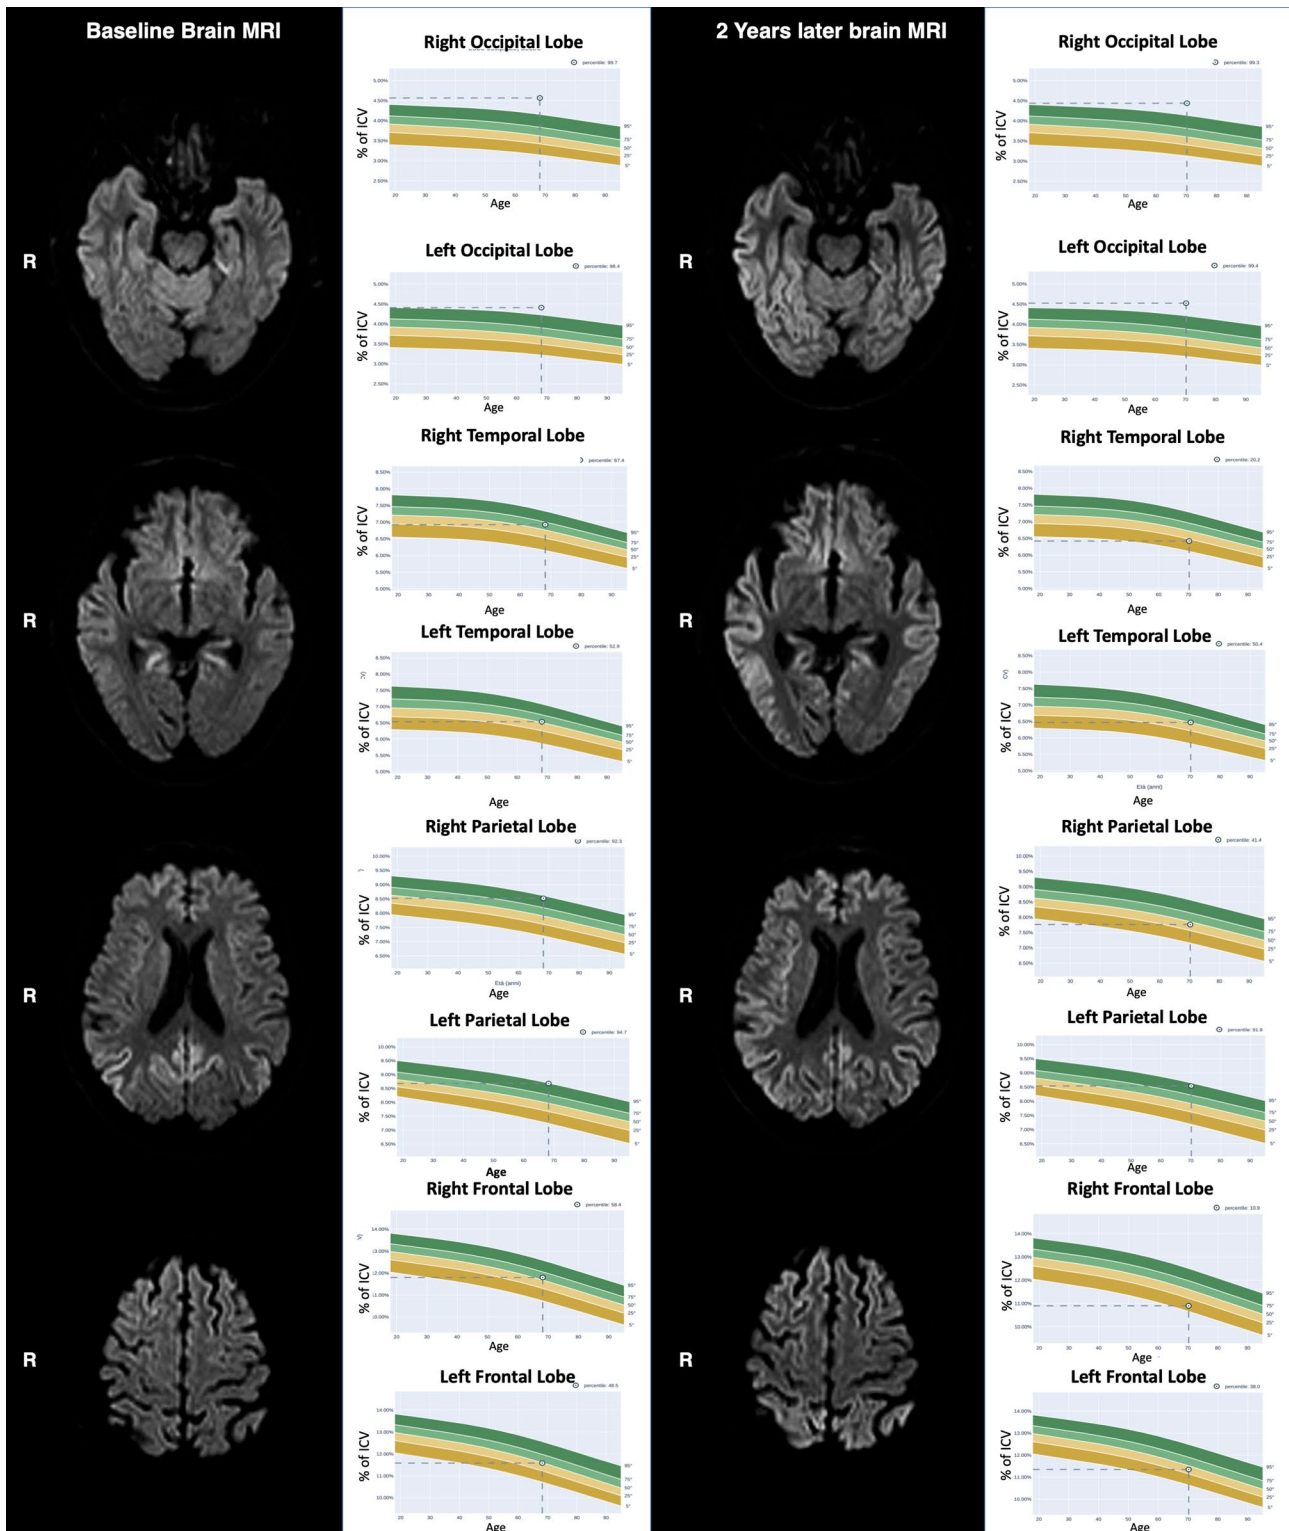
The figure shows the DWI sequence of the brain MRI at baseline and after 2 years. Additionally, the values of the cerebral lobe volumes of our patient, as a percentage of total intracranial volume (ICV) corrected for age, are reported in relation to normative values
